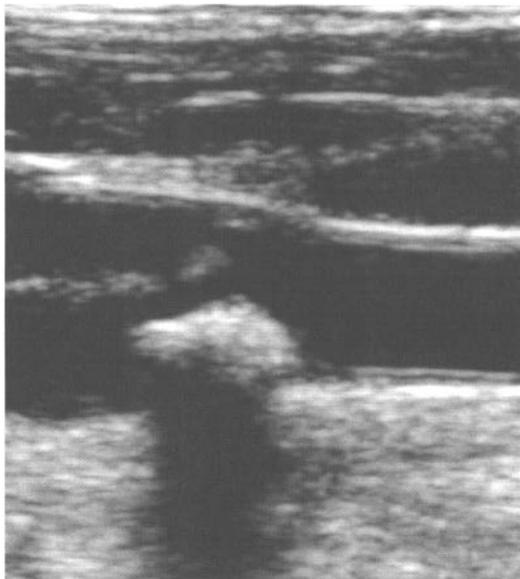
Plaque calcification produces a ‘shadow’ artifact on B-mode scan, or the dark area due to poor or no ultrasound penetration underneath a bright reflector.
